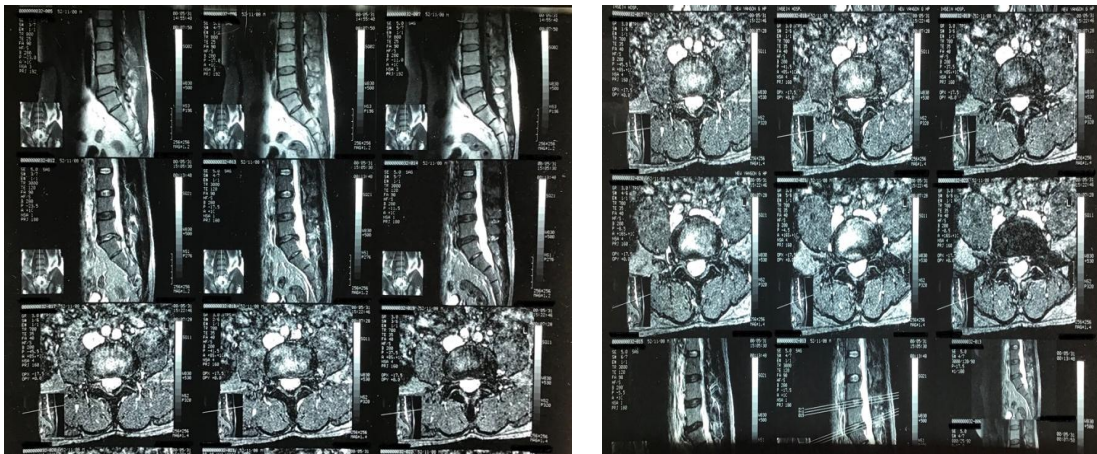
Lumbar MRI before operation
